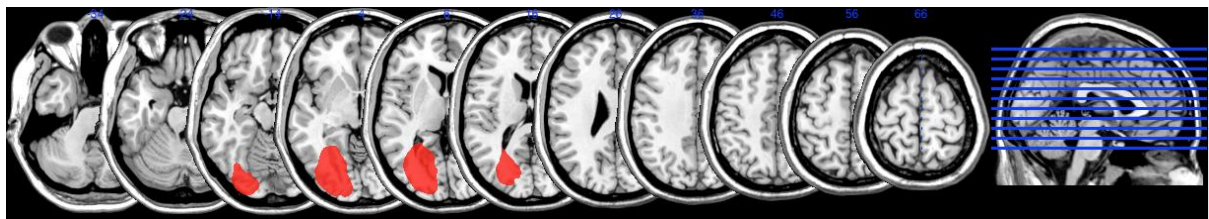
MRI scan of patient GM
